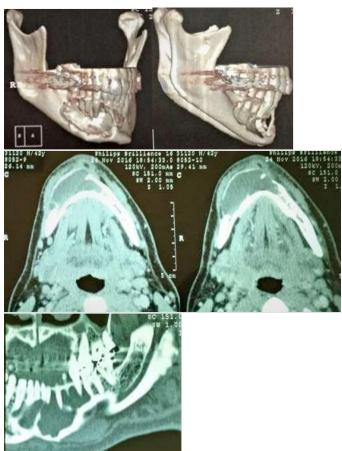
Initial CT scan showing bony lesion
